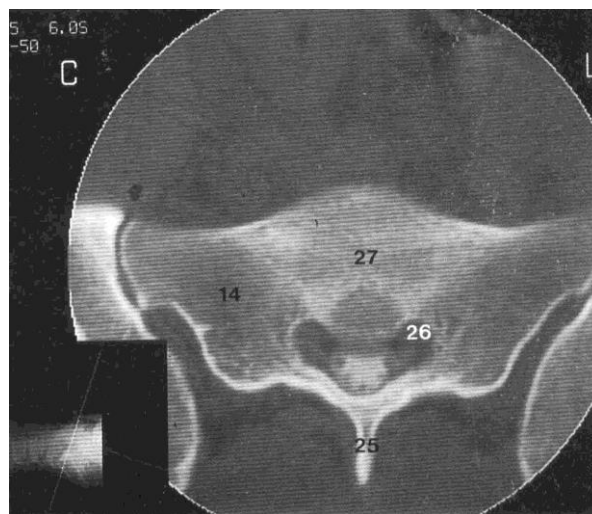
Axial CT images at level of sacrum with intrathecal contrast injection showing different parts of it (*Quoted from Weir et al., 1997*).
